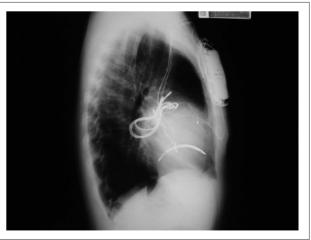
Chest x-ray in AP and side views. Patient with ICD on the right side due to previous pacemaker implant, thus maintaining the prior surgical site. The patient presented DFT above the maximum shock energy of the implanted device and needed external defibrillation. Additional shock electrode (array) implant in the epicardial region with decrease in DFT by 10J.
